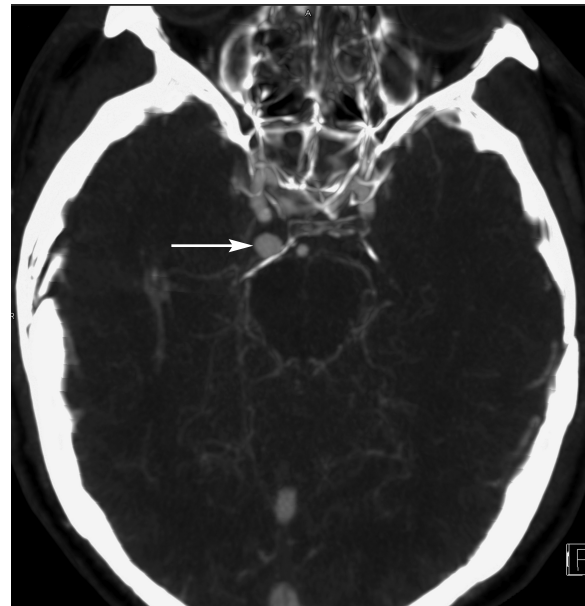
Thick slab axial MIP; CT-angiography 24 hours after trauma demonstrates filling of an aneurysm in the area with the most massive subarachnoid hemorrhage (arrow). Note the anterior and left dislocation of the posterior clinoid process.
